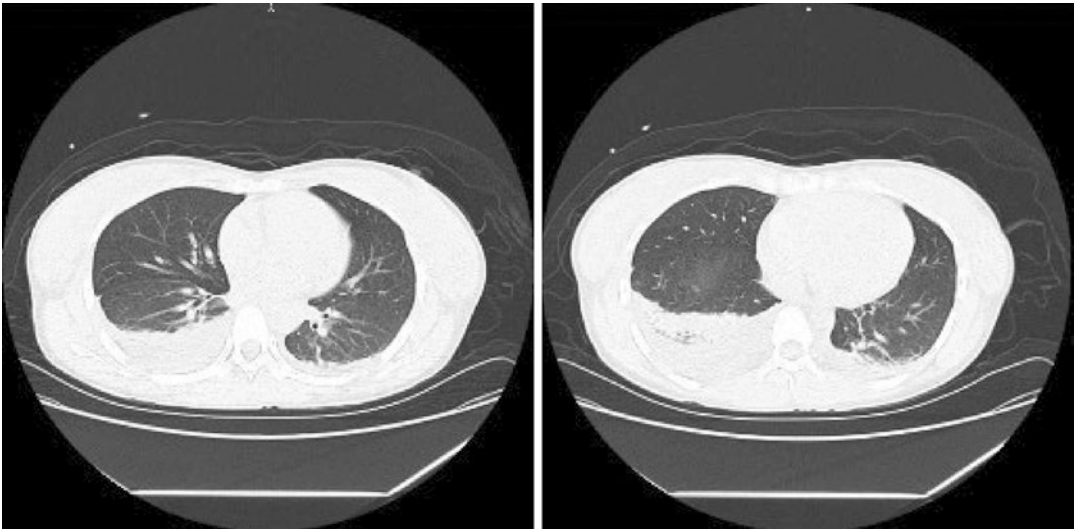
Chest CT showing bilateral interstitial lung inflammation. Bilateral pleural effusion, with partial expansion of both lower lungs
